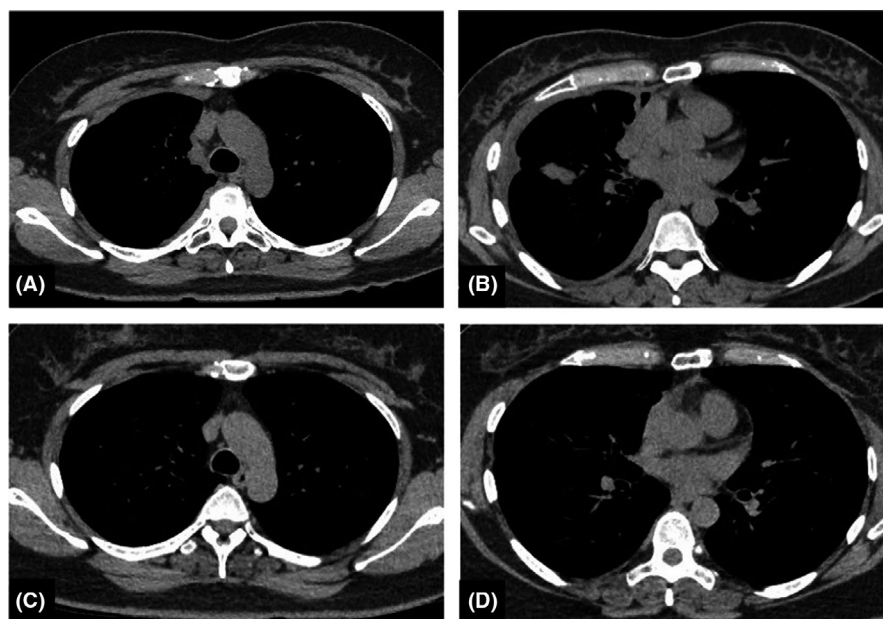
Chest computed tomography shows improved pleural disease after cytotoxic chemotherapy (A, B: after two cycles of cisplatin and pemetrexed) (C, D: after 29 cycles of maintenance pemetrexed, leading to a complete response)
